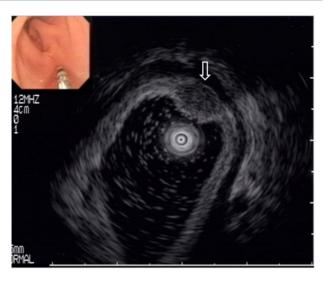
Endoscopic ultrasonography (Miniprobe 12 MHz, Olympus, Tokyo, Japan) shows an oval, well-defined, inhomogeneous hypoechoic tumor with an irregular outer margin involving the muscularis mucosa and submucosa layer (arrow).
